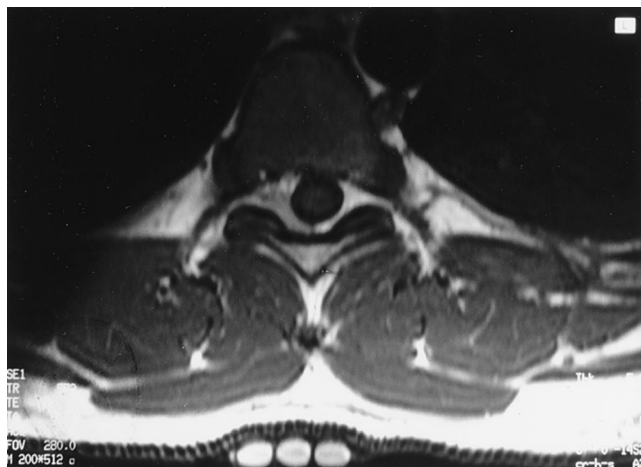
T1-weighted axial image (TR = 572, TE = 15) at T7–T8 shows an extradural mass displacing the thecal sac to the left.
